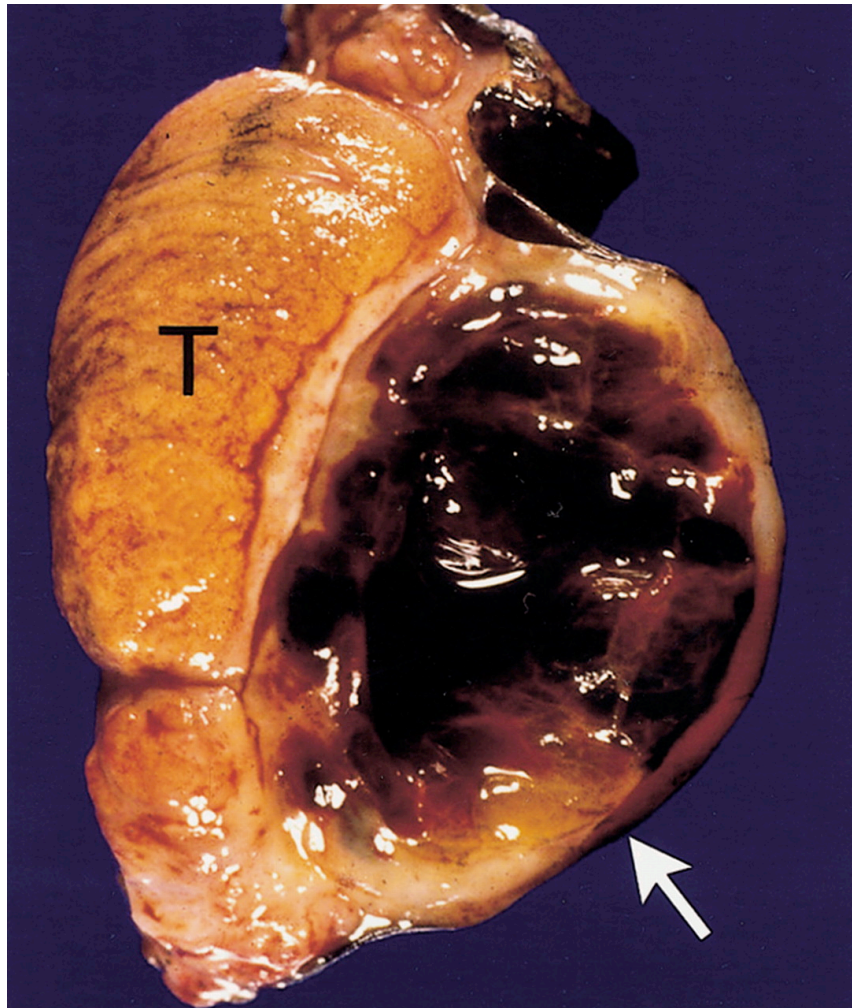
This image shows a large hematocele (arrow) compressing the normal testicular parenchyma. T = testis. (radiographics.rsna.org)
